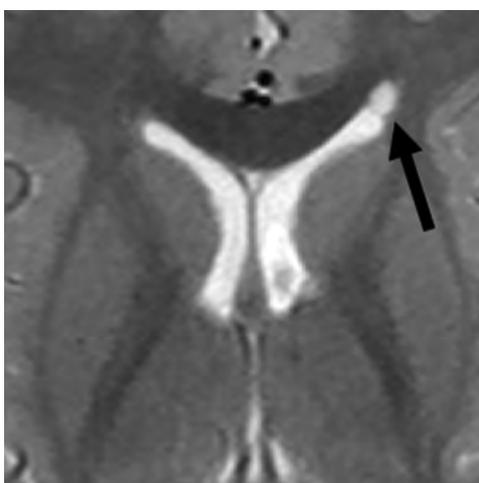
Coarctation of the frontal horn. Axial T2-weighted MR image from a 3-year-old boy showing coarctation of the left frontal horn with connatal cyst formation (black arrow).
